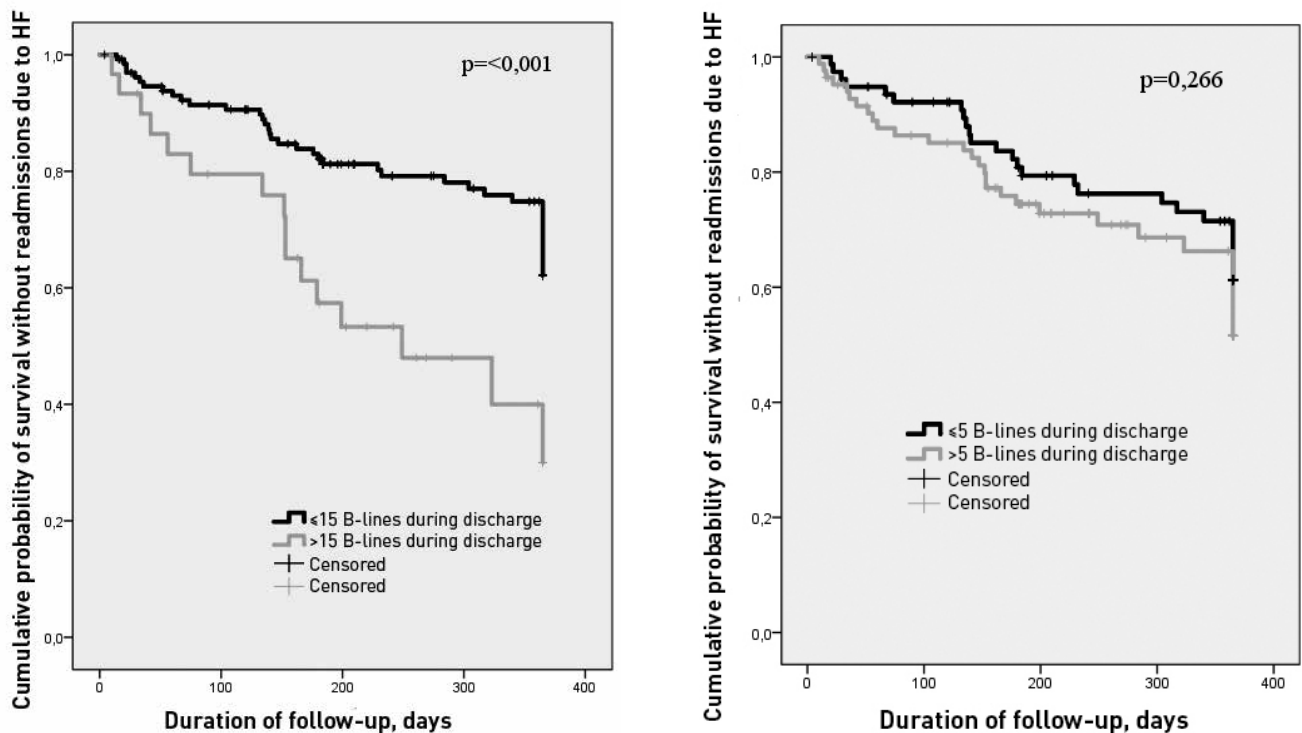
Kaplan Meier curves for cumulative probability of survival without readmissions due to HF depending on the presence and severity of lung congestion according to lung ultrasound during discharge.
